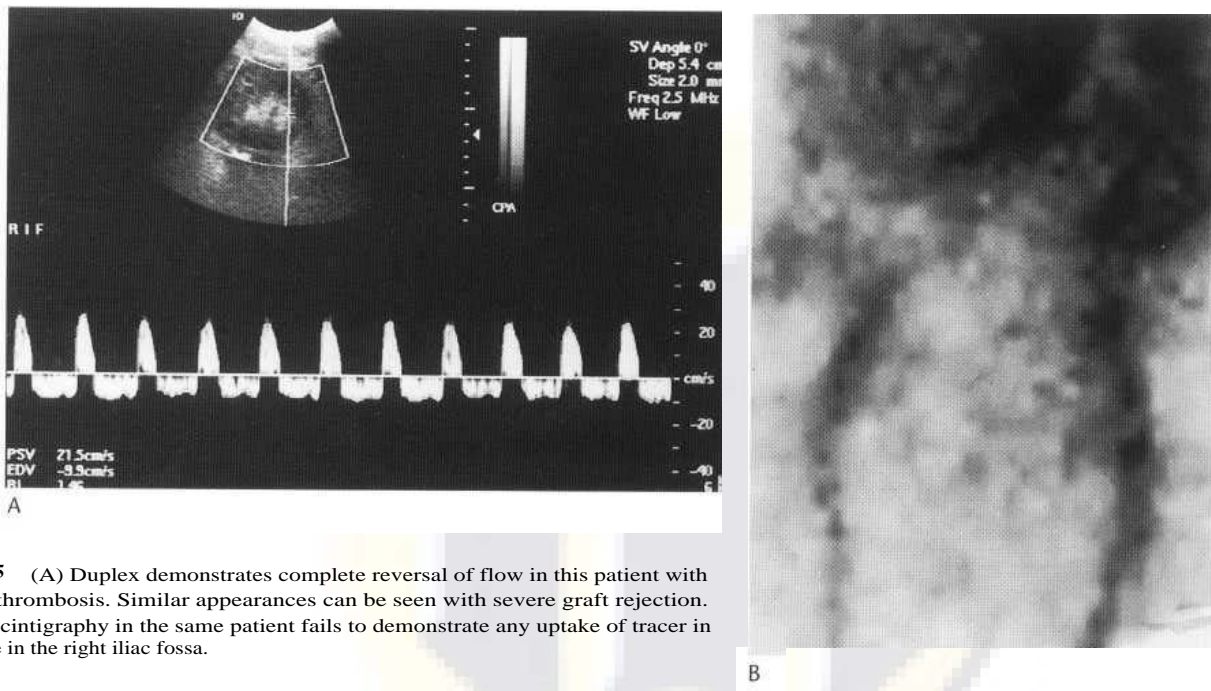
(A) Duplex demonstrates complete reversal of flow in this patient with renal vein thrombosis. Similar appearances can be seen with severe graft rejection. (B) Renal scintigraphy in the same patient fails to demonstrate any uptake of tracer in the graft site in the right iliac fossa.
